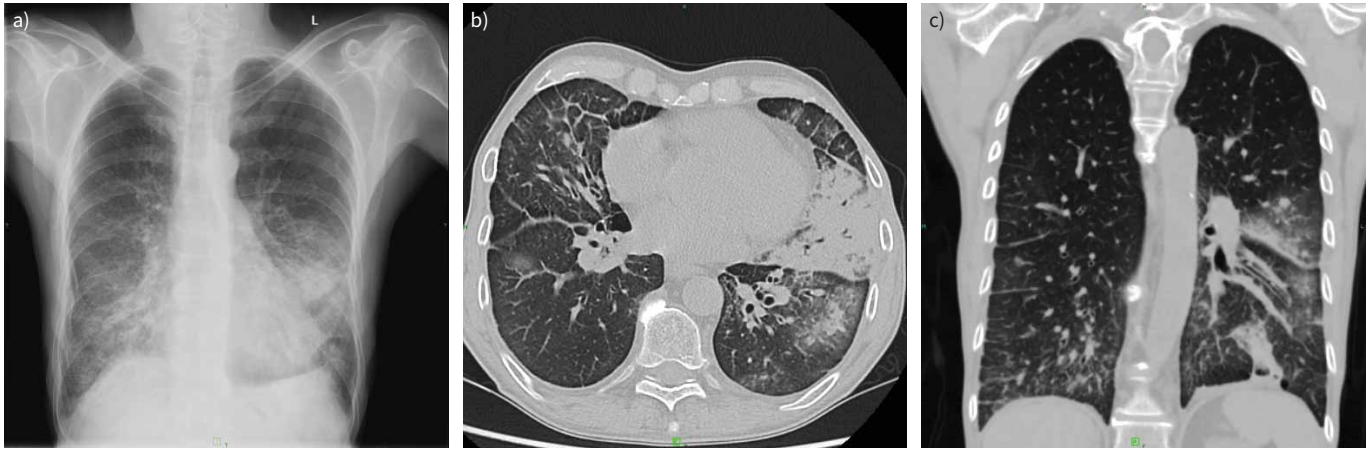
59-year-old male patient with a history of sublingual cancer with a sudden onset of dyspnoea. a) Chest radiograph demonstrated infiltrates and ground-glass opacity in basal distribution. Coronavirus disease 2019 (COVID-19) was suspected; therefore, a computed tomography (CT) scan was requested. b) Axial and c) coronal CT images depicted patchy nodular consolidations in the right lobe and in the left lung, mainly in peribronchial localisation. Extensive ground-glass regions could be observed around these areas. In the ventrobasal part of the left segment S3, a triangular consolidation area with a black bronchus sign was also detected, and a similar consolidation in the left S10. Bilateral few band-like lesions and pleural effusion were also visible. The depicted pulmonary abnormalities primarily indicated bronchopneumonia; COVID-19 pneumonia was considered less likely (CO-RADS category 2 (COVID-19 Reporting and Data System)).
